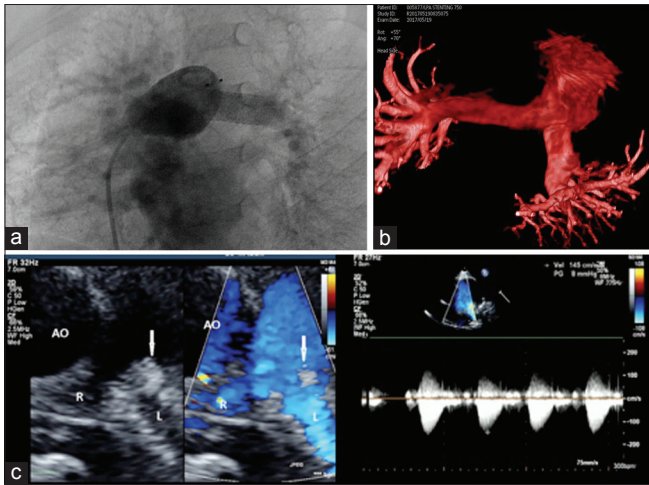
(a) Fluoroscopic image showing stent and Amplatzer Ductal Occluder II device *in situ* with good flow in left pulmonary artery. (b) Three-dimensional rotational angiography demonstrating relief of left pulmonary artery origin stenosis with stent angioplasty. (c) Two-dimensional echocardiography and color Doppler-stent and Amplatzer Ductal Occluder II device *in situ* with good flow in left pulmonary artery
